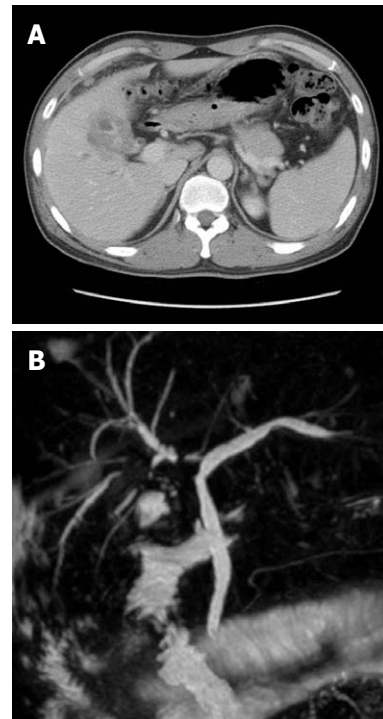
Abdominal computed tomography. A: Diffuse low-attenuated wall thickening of the gallbladder; B: Magnetic resonance cholangiopancreatography reveals a severe segmental stricture of the right intrahepatic bile duct with mild upstream duct dilatation.
